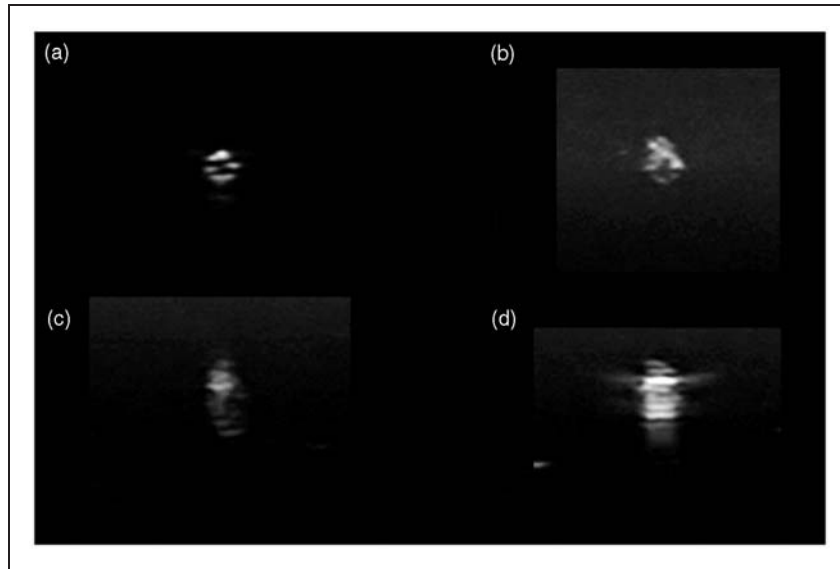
The Saphyon Venaseal catheter tip in transverse plane, with ingenious patented design to ensure a characteristic ultrasound signature when scanned perpendicularly (a), but beginning to become distorted at an insonation angle of 45° (b), an unrecognisable at an angle of 60° (c). The tip still blurred at 60°, becomes more echogenic with an air bubble at the tip, enabling safer positioning (d).
